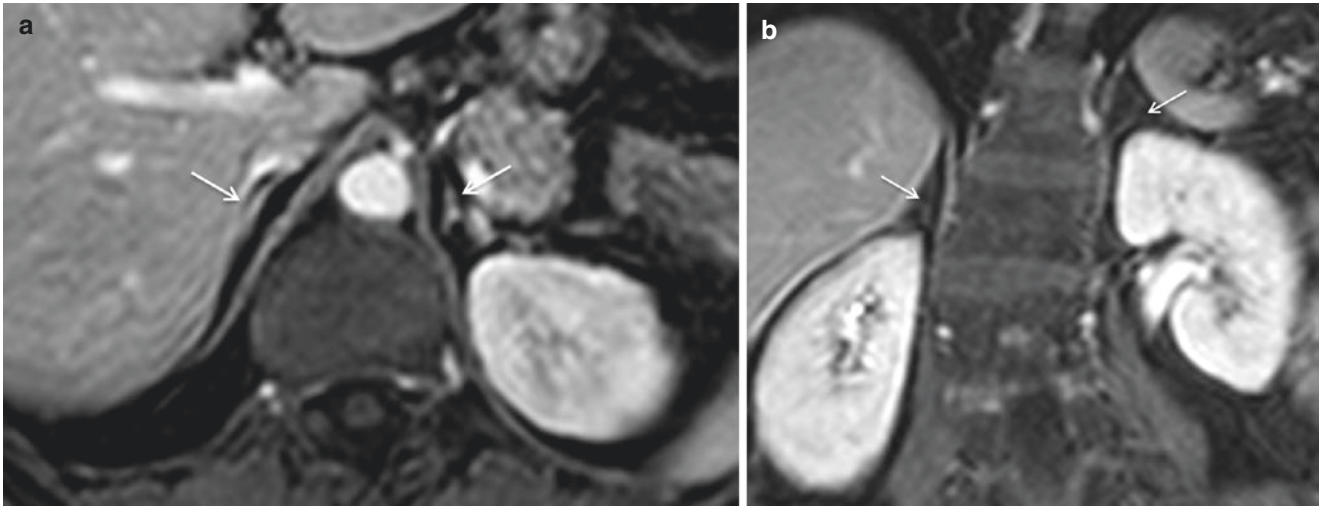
Primary adrenal insufficiency secondary to autoimmune disease. Axial (a) and coronal (b) post-gadolinium T1-weighted images showing very small adrenal glands due to accentuated atrophy (*white arrows*)
